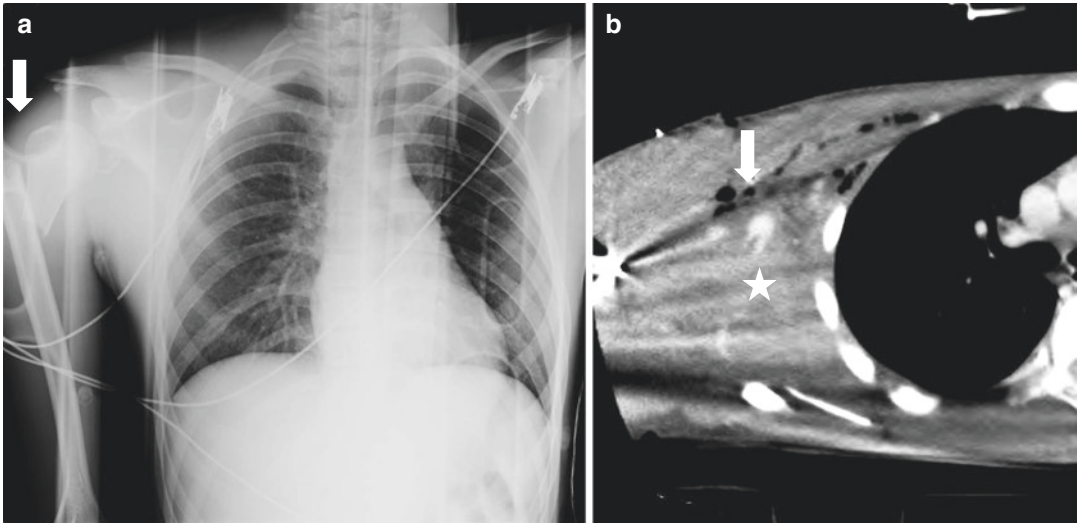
Chest X-rays after MVA in a 14-year-old patient showing humeral shaft fracture with medial dislocation of the humeral head (arrow in a). Intraluminal axillary artery thrombosis (star in b) and subcutaneous emphysema (arrow in b)
